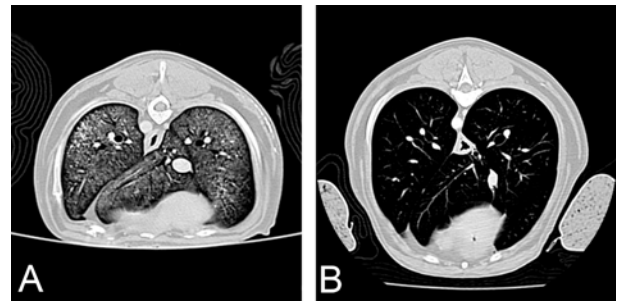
Transverse computed tomographic image at the level of the cranial aspect of the diaphragm of the patient in this case (A) and another patient considered normal regarding pulmonary findings with the same window width and window level (B). The pulmonary parenchyma of the hyperadrenocorticism case shows diffuse ground-glass attenuation in bilateral caudal and accessory lung lobes and hyperattenuated miliary nodules in the dorsal region of the left caudal lung lobe.
